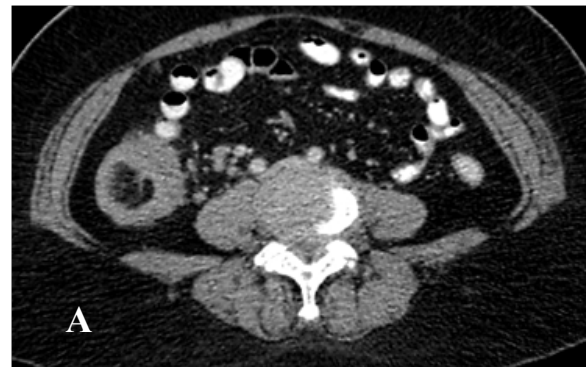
CT Scan showed endoluminal mass with multiple septation arising from lateral wall of caecum.
